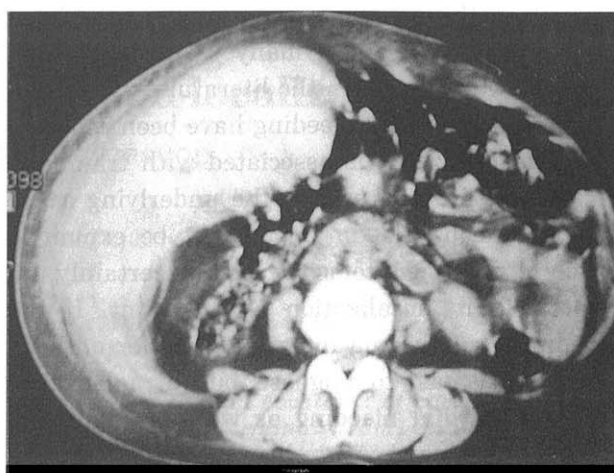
CT scan of the abdomen, showing a large heterogeneous mass occupying most of the right half.
